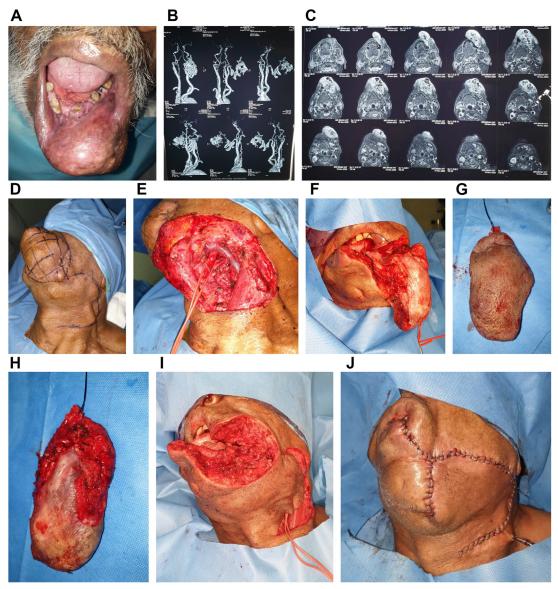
Case 4: (*A*) High-flow vascular malformation of lower lip with asymmetry. Fig. 4B of case 4: Preoperative CT angiogram showing isolated feeders from ECA. Fig. 4C of Case 4: Preoperative contrasted MRI scan axial views demonstrating the intense vascular perfusion, flow voids, and lip deformation. Fig. 4D of Case 4: planned surgical incision and area of the lesion cross hatched for excision; (*E*) High-flow vascular malformation of lower lip with asymmetry. External carotid artery identification and control with vascular loop. (*F*–*H*) High-flow vascular malformation of lower lip excision. (*F*) Intraoperative picture with ECA control and post excision; (*G*, *H*) cutaneous and mucosal surface. Case 4: (*I*) High-flow vascular malformation of lower lip excision.
